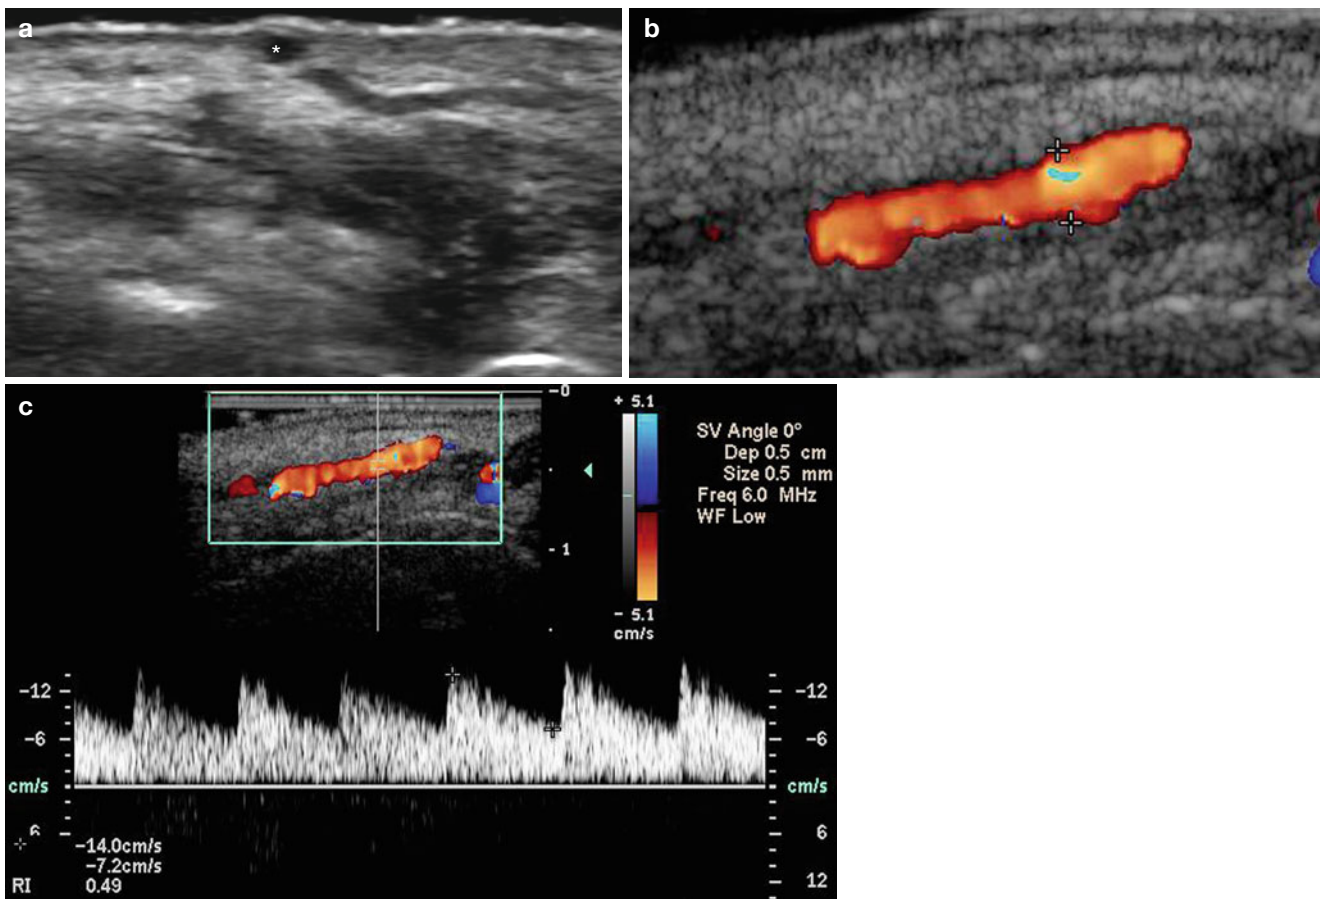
(a–c) Caliber persistent artery of the lip. (a) Ultrasound (gray scale, transverse view) shows an anechoic round shaped nodule (*) in the dermis close to a tubular anechoic tract. (b) Color Doppler ultrasound (oblique view) demonstrates flow within the superficial
